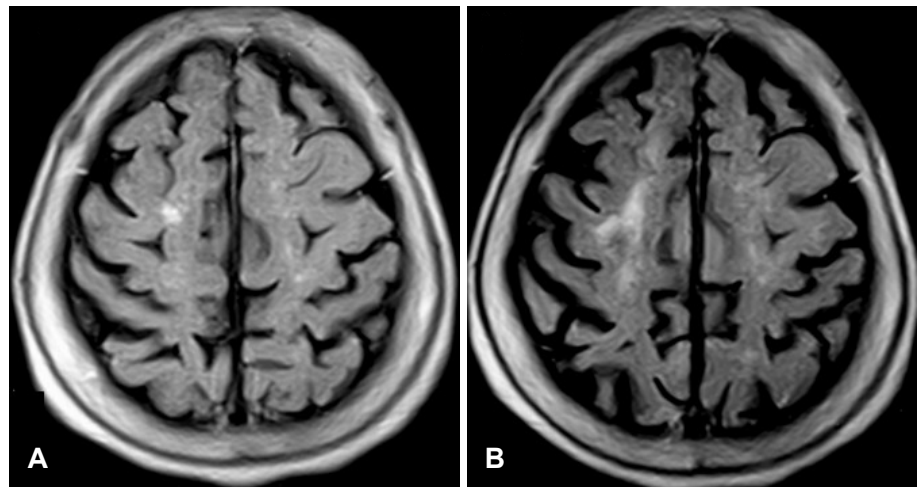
In comparison with brain MRI (A) which had been checked two months before the onset of symptom, re-checked brain MRI (B) showed a newly developed small cortical infarction in the right superior frontal gyrus which was checked 13 days after the onset of symptoms.
